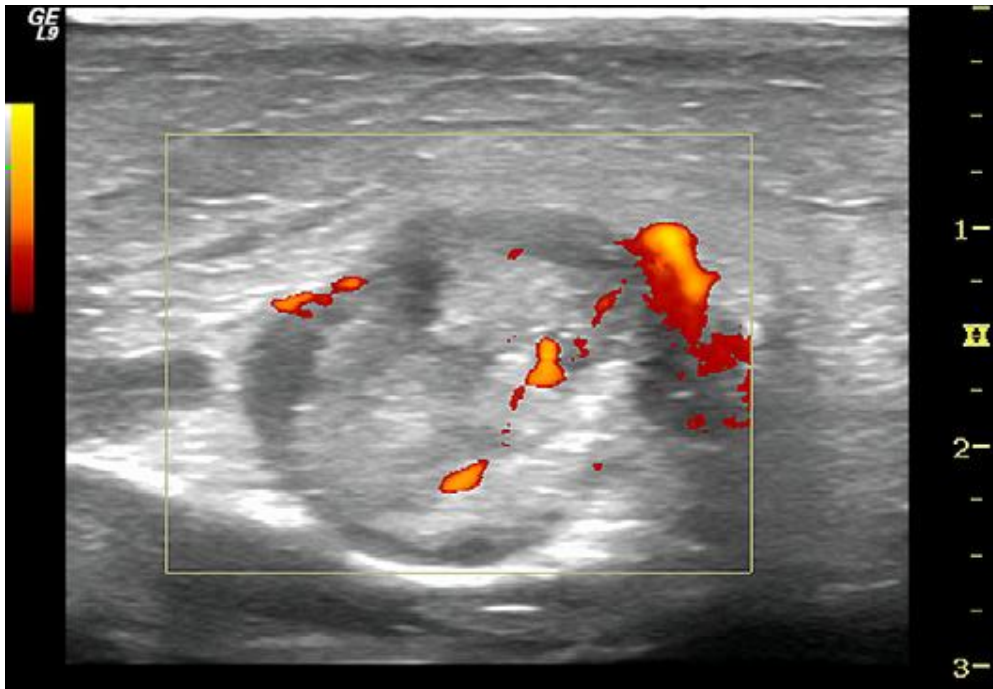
Transverse sonogram and Doppler of a left parotid. Typical aspects of parotid abscess. (Philips Katz et al.)
